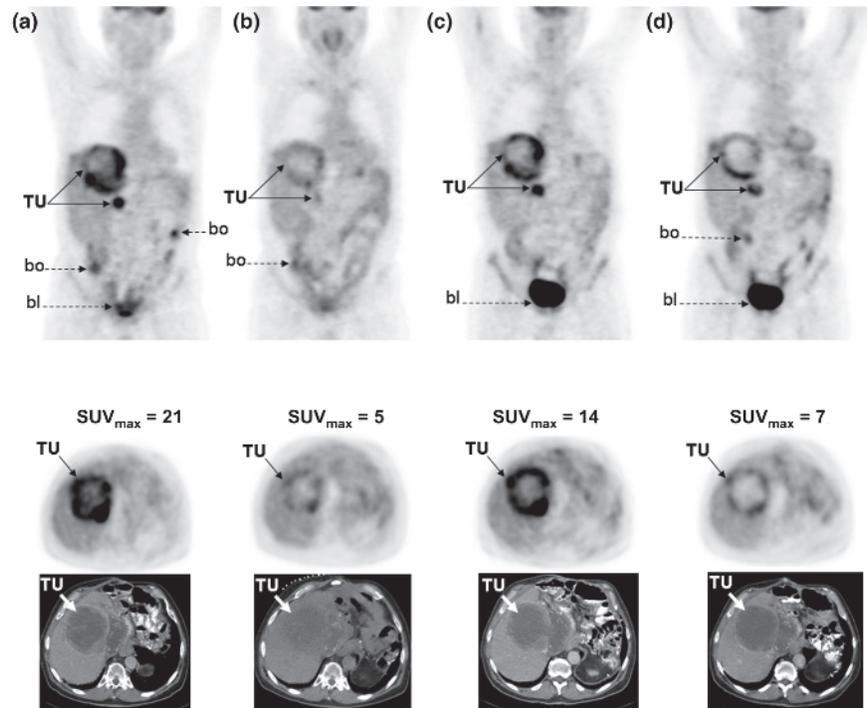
Coronal (top), axial (middle) FDG-PET slices, and corresponding axial CT slices (bottom) in a patient with GIST metastatic to the liver and anterior abdomen (solid arrows, TU) before sunitinib therapy (a, baseline), during cycle 1 (b), at the end of the resting period before cycle 2 (c, off treatment), and during cycle 4 (d). Physiologic uptake of FDG is seen in the bowel (dotted arrows, bo), and in the urinary bladder (dotted arrows, bl). The baseline FDG-PET (a) shows a large FDG-avid mass with a necrotic center in the liver and a SUV_{max} of 21, and a smaller mass in the anterior abdomen reflecting intense tumor glycolytic activity (solid arrows, TU). A marked decrease in glycolytic activity is noted in both tumor masses (solid arrows, TU) as early as 1 week following treatment with sunitinib during cycle 1 (b). The SUV_{max} of the liver lesion has decreased to 5. Note that the rebound in Glycolytic tumor activity in both masses (solid arrows, TU), as reflected by intense FDG uptake and an increase in the SUV_{max} of the liver lesion to 14, at the end of the resting period before the next cycle of sunitinib (c). During subsequent cycles of sunitinib therapy, a decrease in tumor metabolic activity is again observed (d, cycle 4). The SUV_{max} of the liver lesion has decreased to 7 during cycle 4. Note that the size of the hepatic lesion does not significantly change on the corresponding CTs obtained at the same time points (bottom, white arrows, TU). *Source:* Courtesy of Annick D. Van den Abbeele, MD and Iryna Rastarhuyeva, MD, Dana-Farber Cancer Institute, Boston, MA.
